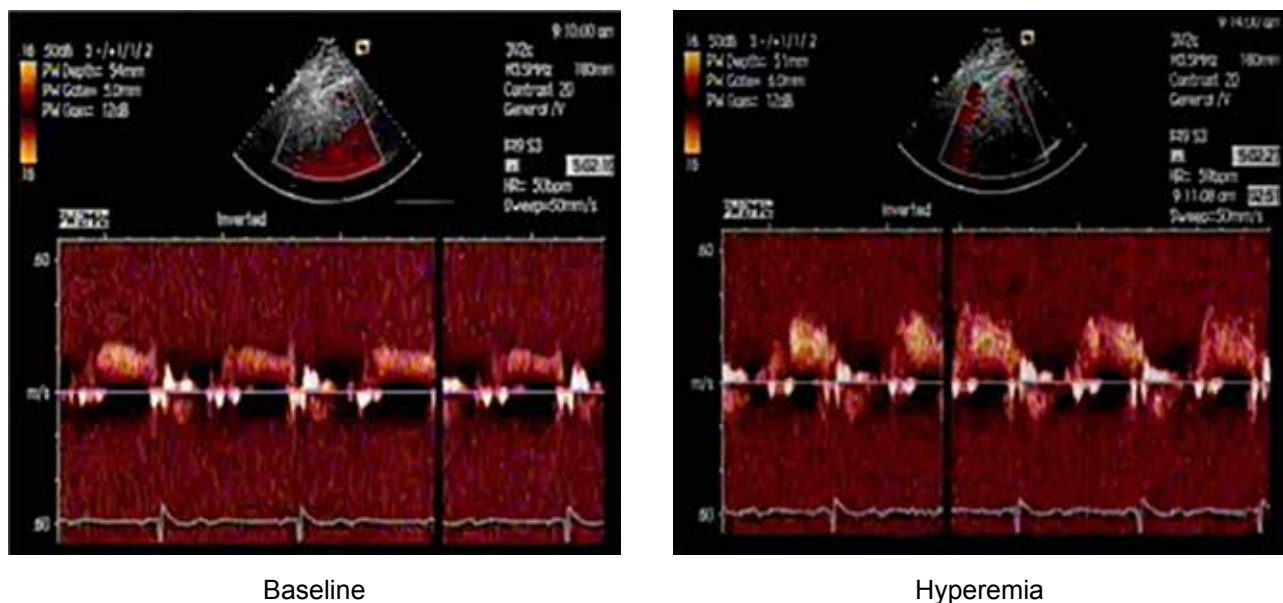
Demonstration of coronary flow velocity at baseline and hyperemia obtained by transthoracic pulsed-wave Doppler echocardiography in the distal left anterior descending coronary artery.
